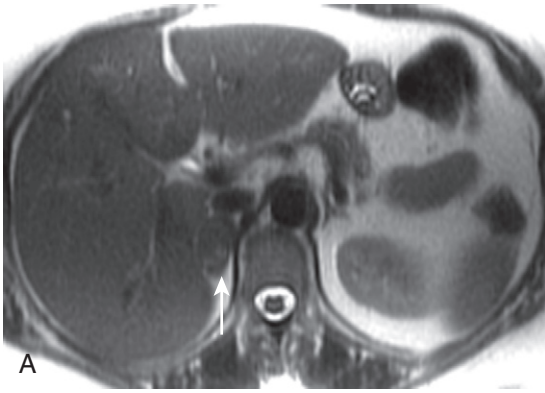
Adrenal myelipoma. A, On the T2-weighted image, a lesion occupying the right suprarenal space (*arrows*) blends with retroperitoneal fat—inconspicuous, despite its large size. Signal loss on the T2-weighted fat-suppressed (B) image and hyperintense signal on the in-phase image (C), maintained on the out-of-phase image (D), characterize macroscopic fat (*arrows*). Expected signal loss on the T1-weighted fat-suppressed image (E) and lack of enhancement on the postcontrast image (F) is observed in an AML (*arrows*) mostly composed of fat.
